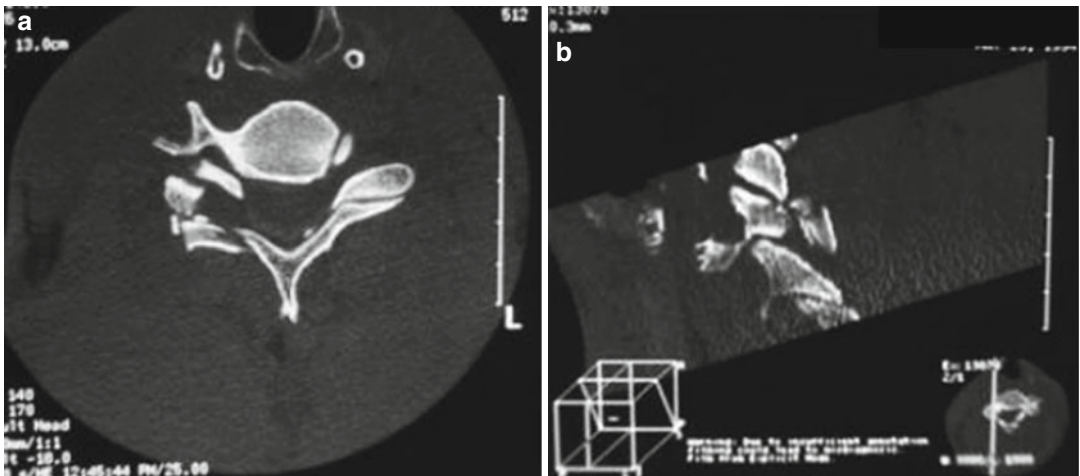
(a, b) Thin-cut CT shows unilateral facet injury
